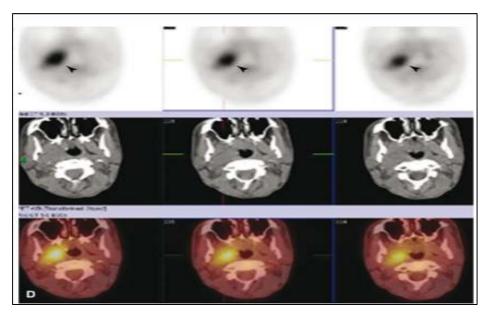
Positron emission tomography (PET) scan fused with the corresponding CT slices reveals hypermetabolism within the right skull base mass (arrowheads) (Perry and Brat., 2010).
